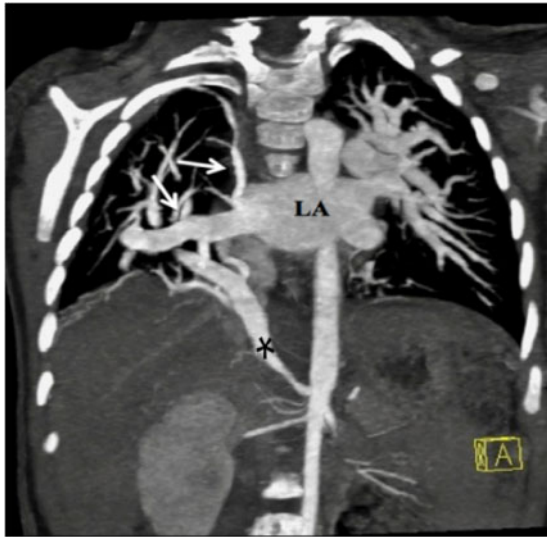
Maximum intensity projection image in a coronal plane of the computed tomography scan demonstrating the right pulmonary veins and their connection to the left atrium (white arrows). The aortopulmonary collateral arising from the abdominal aorta to the right lung is also seen (*). LA, left atrium.
